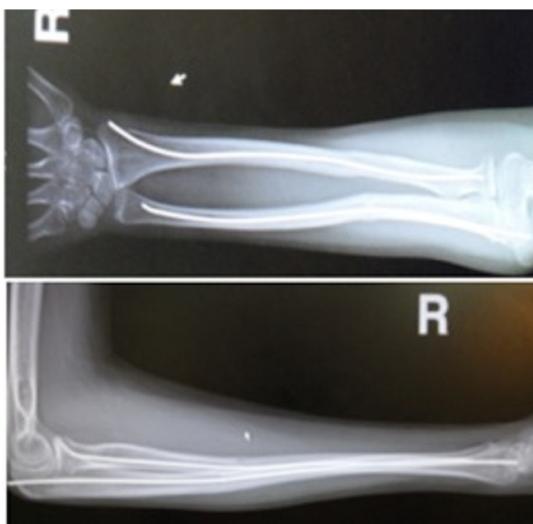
Anteroposterior X-ray (Top) and lateral view (bottom) shows radiological union of the fracture
